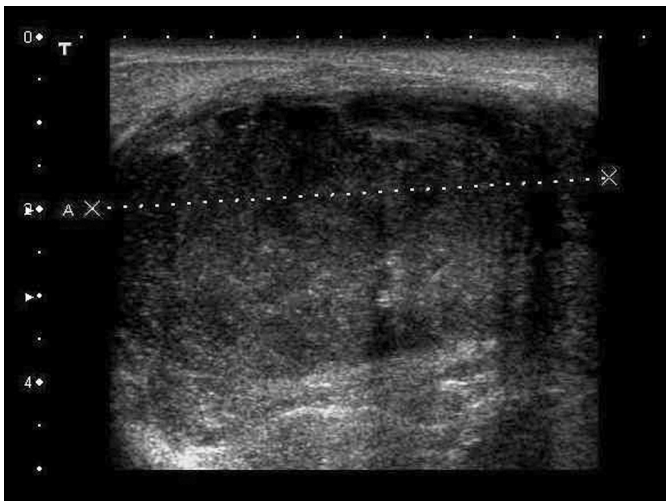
Ultrasonography reveals a mass of 12 cm. with irregular border.
